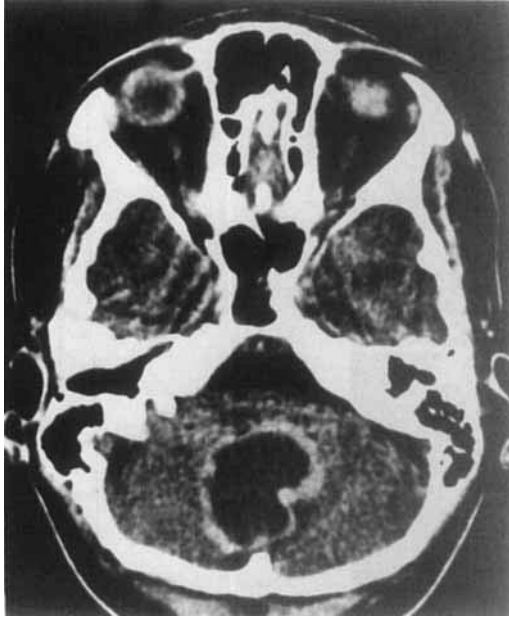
Cerebral computed tomography scan after contrast material injection. Large cerebellar hypodense (cystic) mass with enhancing ring and mural nodules.
